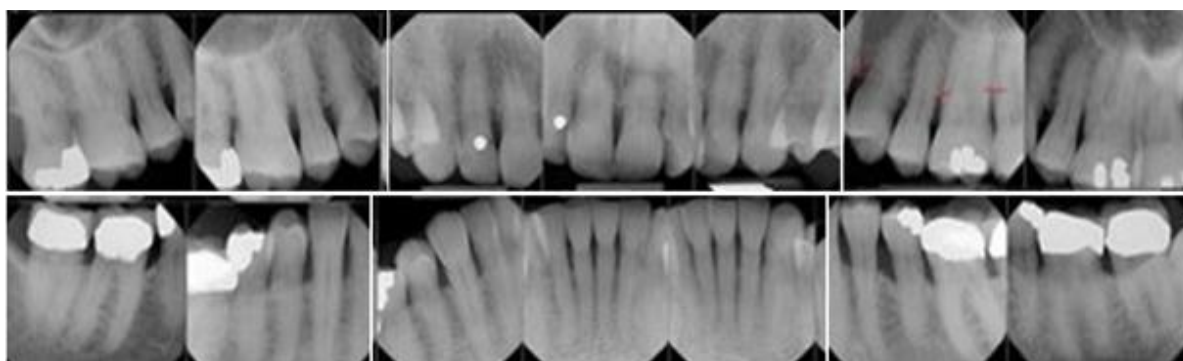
Intraoral radiographs in a patient with localized aggressive periodontitis showed the presence of localized angular bony defects associated with clinical attachment loss in teeth #3, #14 and #19.
